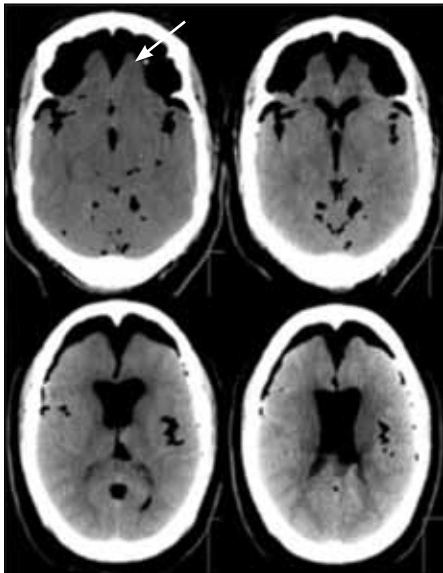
Computed tomography scan of the head showing extensive frontal pneumocephalus with compression and separation of the frontal lobes. The wider inter-hemispheric space between the two lobes is called the Mount Fuji sign (white arrow).
